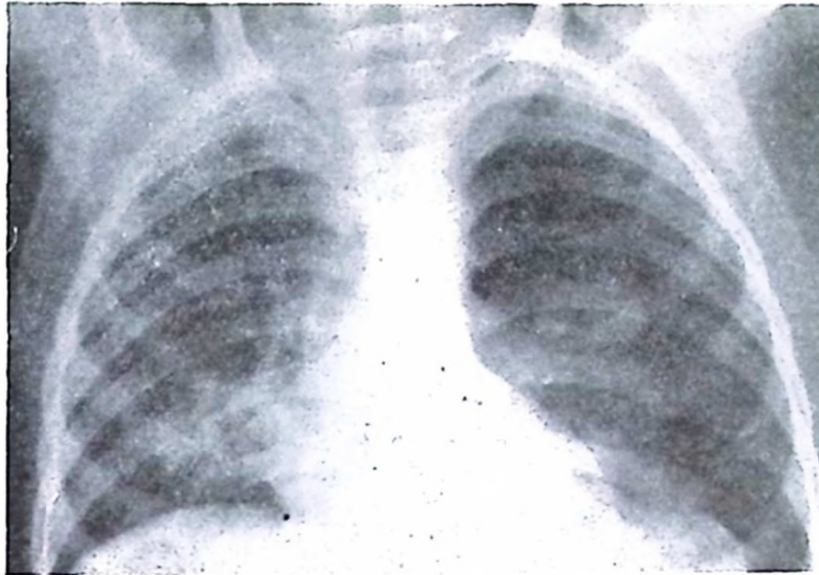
Chest roentgenogram showing pneumothorax on the left side. 10/7/62.
